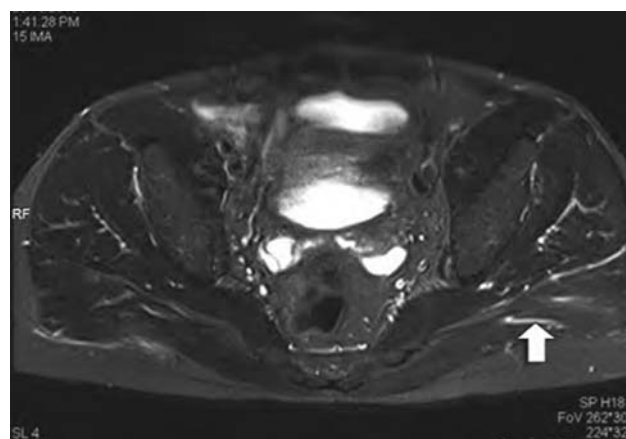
MRI axial STIR sequence shows a brighter signal in the left gluteal muscles (arrow) as compared with its right counterpart, indicative of denervation.
